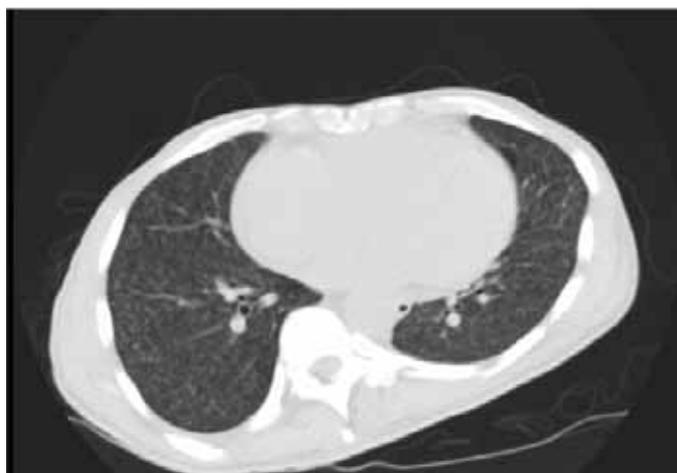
Computed tomography scan of the chest without contrast (axial view).
